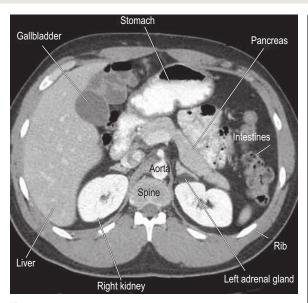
Normal computed tomogram (CT) of the abdomen at L1 level.
